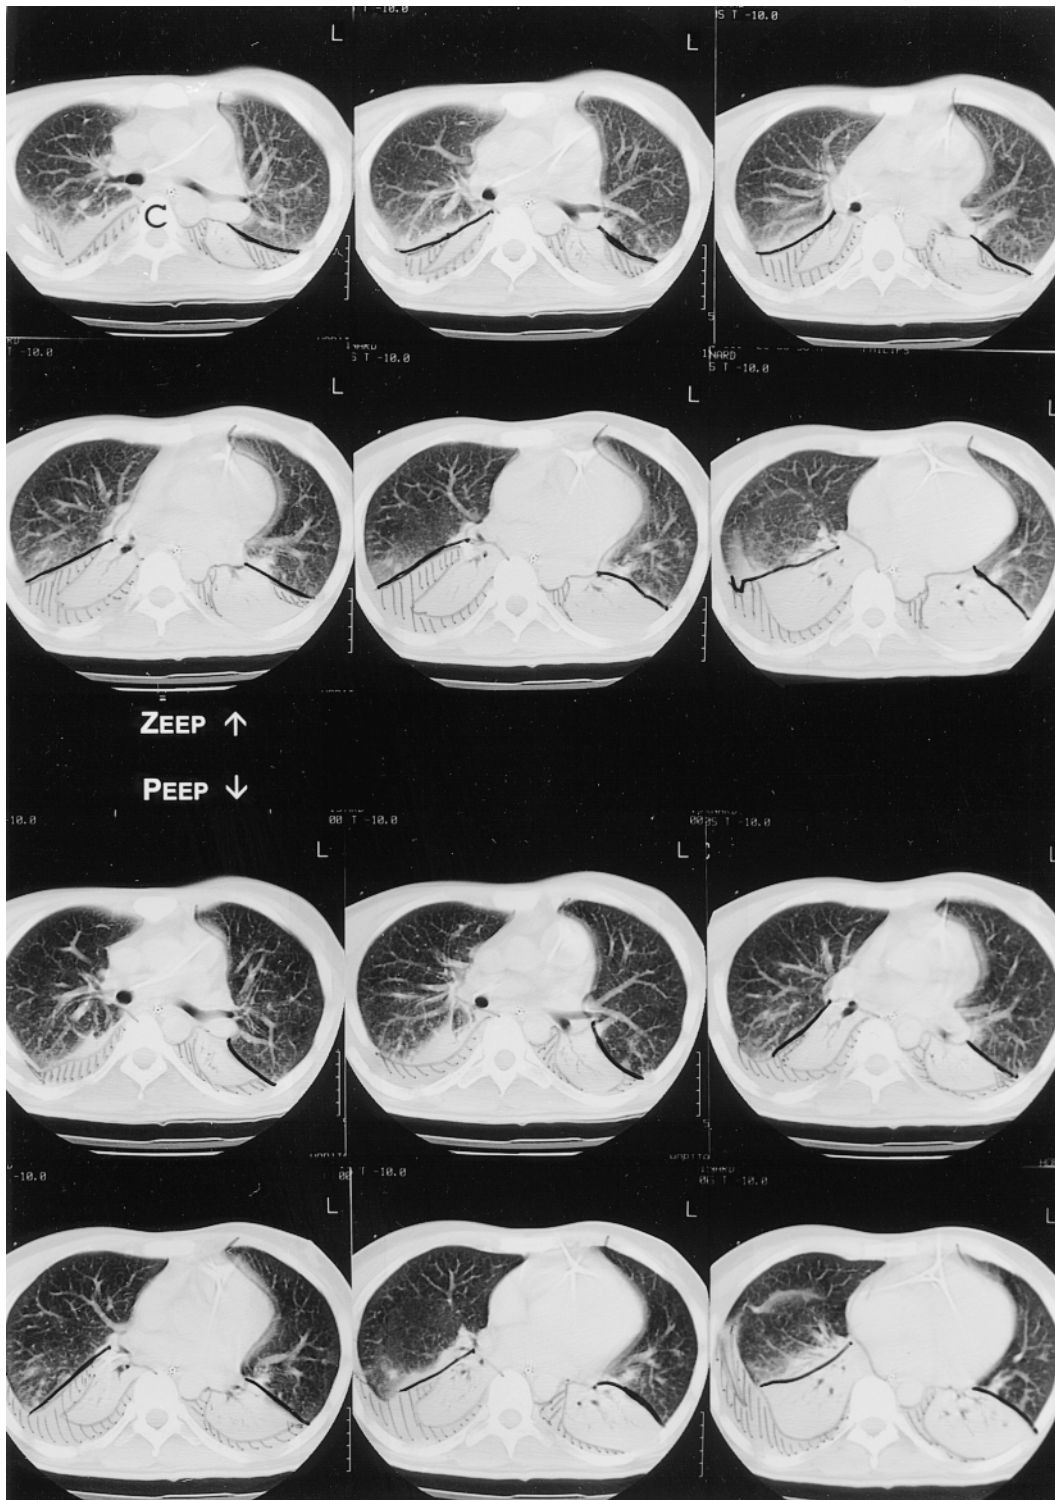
CT scan of a nonrecruiter patient (Patient 14) showing a marked reduction in the volume of lower lobes and no alveolar recruitment with PEEP. The *black line* represents the position of the major fissura. The *hatched areas* represent the pleural fluid. The characteristics of this patient are shown in Tables 1 and 2.
